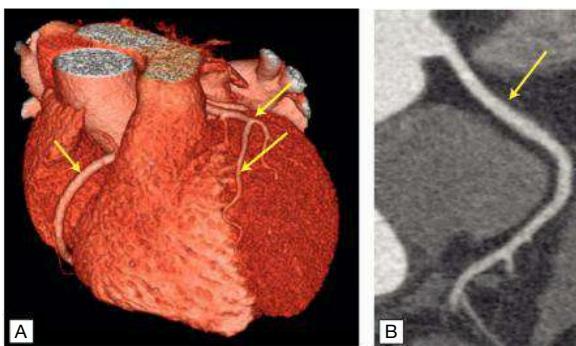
Computed tomography coronary angiography, demonstrating normal coronary arteries (arrows). A Three-dimensional image. B Two-dimensional image.
